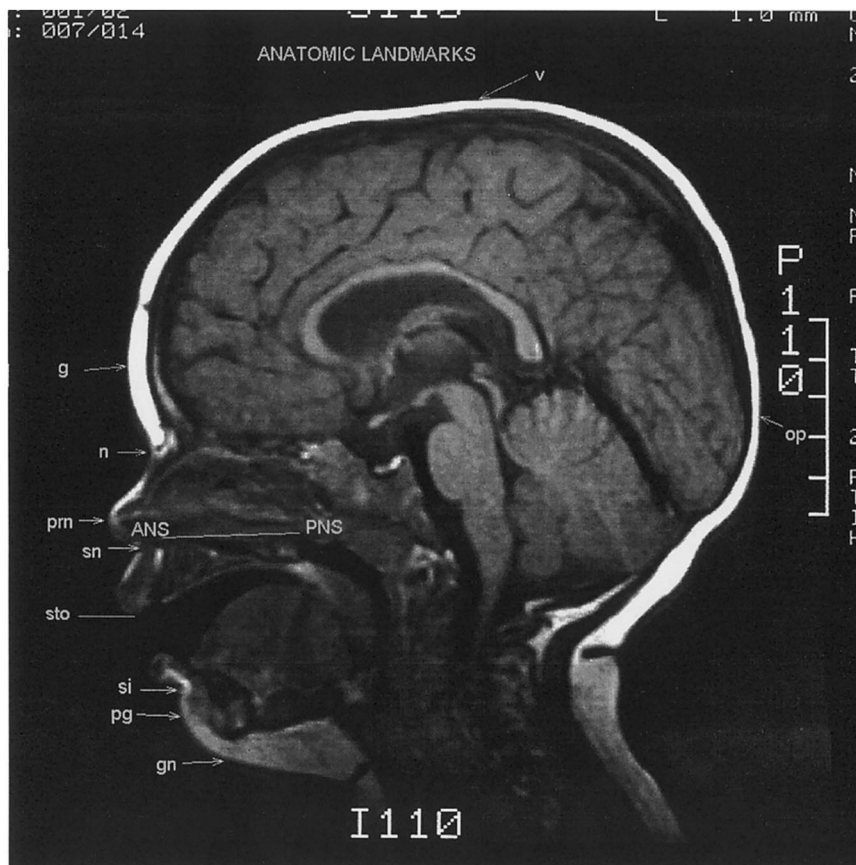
Anatomic landmarks: v, vertex; g, glabella; n, nasion; prn, pronasale; sn, subnasale; ANS, anterior nasal spine; PNS, posterior nasal spine; sto, stomion; si, nasolabial sulcus; pg, pogonion; gn, gnathion; op, opisthocranium. Midsagittal MRI slice of a 1 year, 3 month old male subject.
